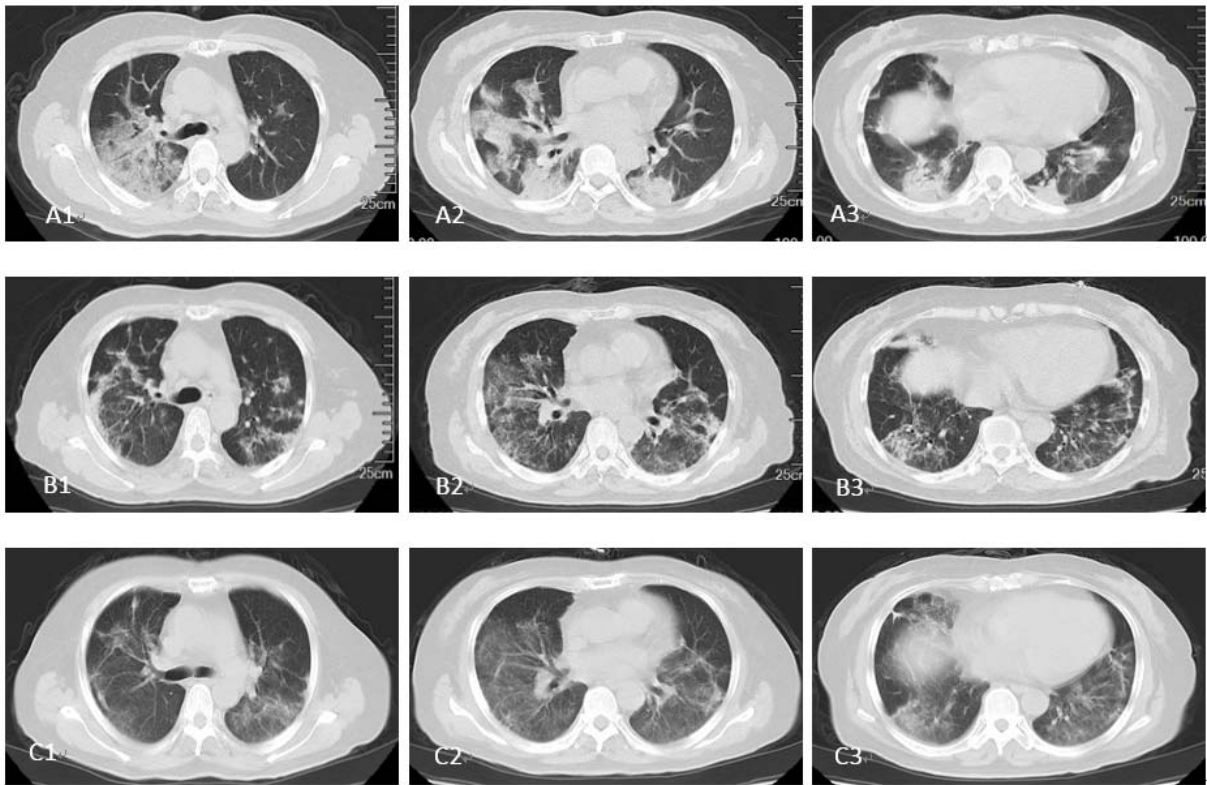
The typical CT images of the lung. A1-A3) CT images on January 29 indicate that there are lesions and mass density increasing shadow in both left and right lung. The ground-glass opacity, nonhomogeneous density, and air bronchus can be seen in the right lung. B1-B3) CT images on February 16 indicate the significant relief in both left and right lung. Only some Stripe shadow and small pieces of ground-glass opacity can be seen. C1-C3) CT images on February 21 indicate the further relief in both left and right lung. Most of the ground-glass opacity lightened, or even disappeared.
